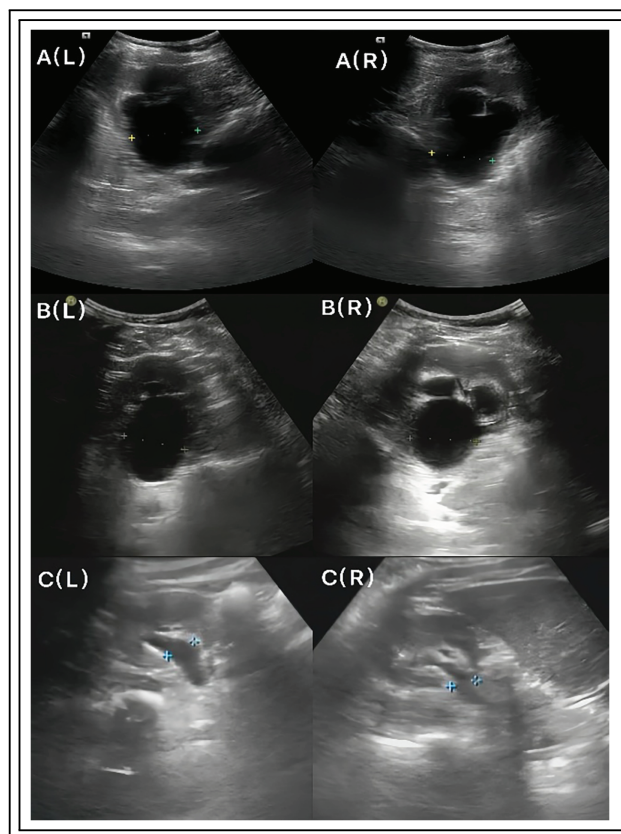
The B-ultrasound images of the kidney. (A) The kidney when the patient did not receive treatment in our department. The anterior-posterior diameter of the left kidney was 39 mm, and the anterior-posterior diameter of the right kidney was 37 mm. (B) The kidney after drug treatment. The anterior-posterior diameter of the left kidney is 31 mm and the anterior-posterior diameter of the right kidney is 33 mm. (C) The kidney after clean intermittent catheterization (CIC). The anterior-to-posterior diameter of the left kidney is 13 mm, and the anterior-to-posterior diameter of the right kidney is 11 mm. Abbreviations: L, Left; R, Right
